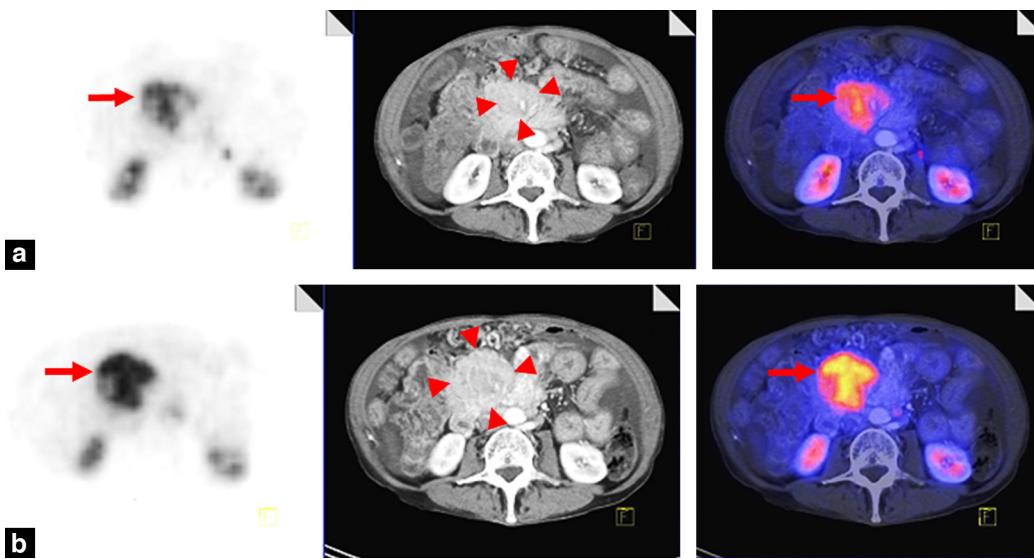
Non-responder to PRRT. A 62-year-old woman with metastasized neuroendocrine tumor of unknown origin (PET, CT, and Fusion). Before (a) and after (b) PRRT with 3755 MBq ^{90}Y -DOTATOC. Post-therapeutic increase of ^{68}Ga -DOTATOC uptake (arrows) and of tumor size (arrowheads), rising tumor markers and deterioration of clinical condition with weight loss. Pre-therapeutic ^{68}Ga -DOTATOC uptake was 11.6; pre-therapeutic assumed ^{90}Y -DOTATOC uptake was 0.6 MBq/g.
